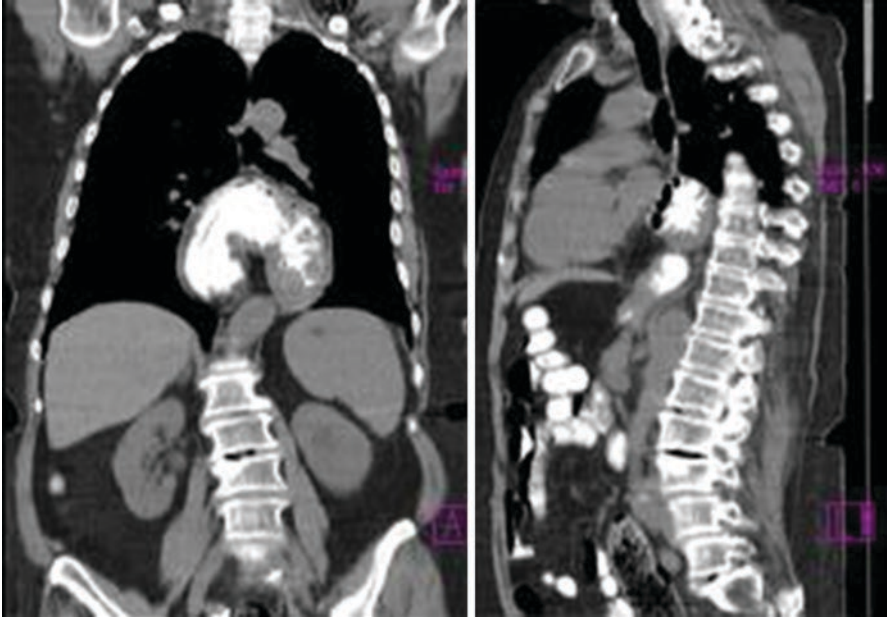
CT appearance of a recurrent hiatal hernia
